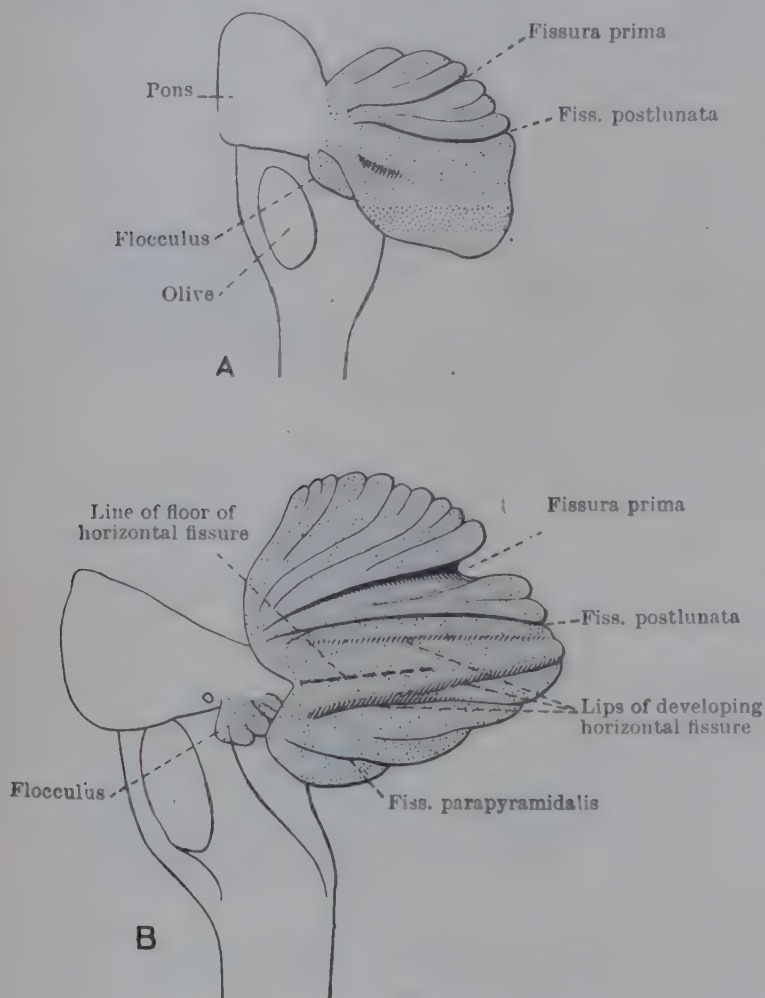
LEFT LATERAL ASPECT OF FETAL RHOMBENCEPHALON AT FOURTH (A) AND FIFTH (B) MONTHS.
